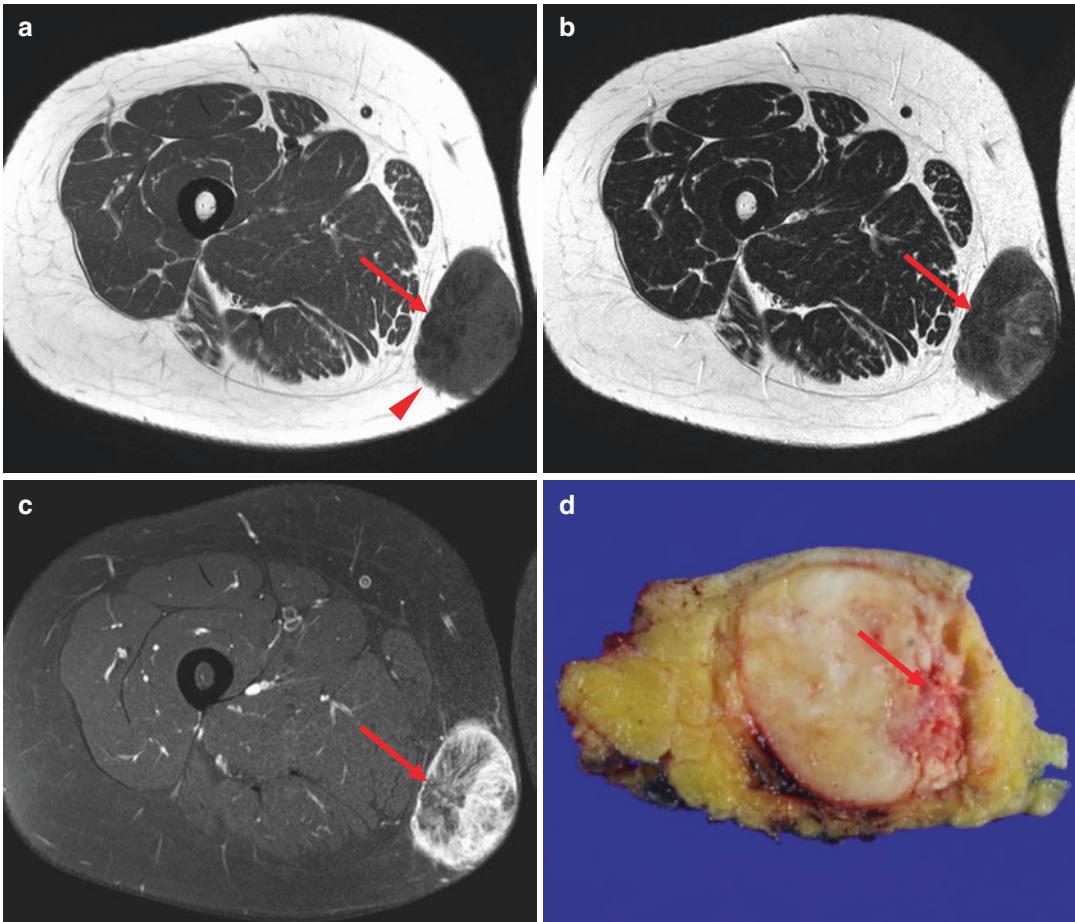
Extraskelatal osteosarcoma. MR image of the thigh reveals a circumscribed, large subcutaneous soft tissue with some infiltrative border (*arrowhead*). The tumor has heterogeneous hypo- to mild hyperintensity to muscle on T1WI (a) and a mixed signal, ranging from dark to hyperintense on T2WI (b), with heterogeneous contrast
